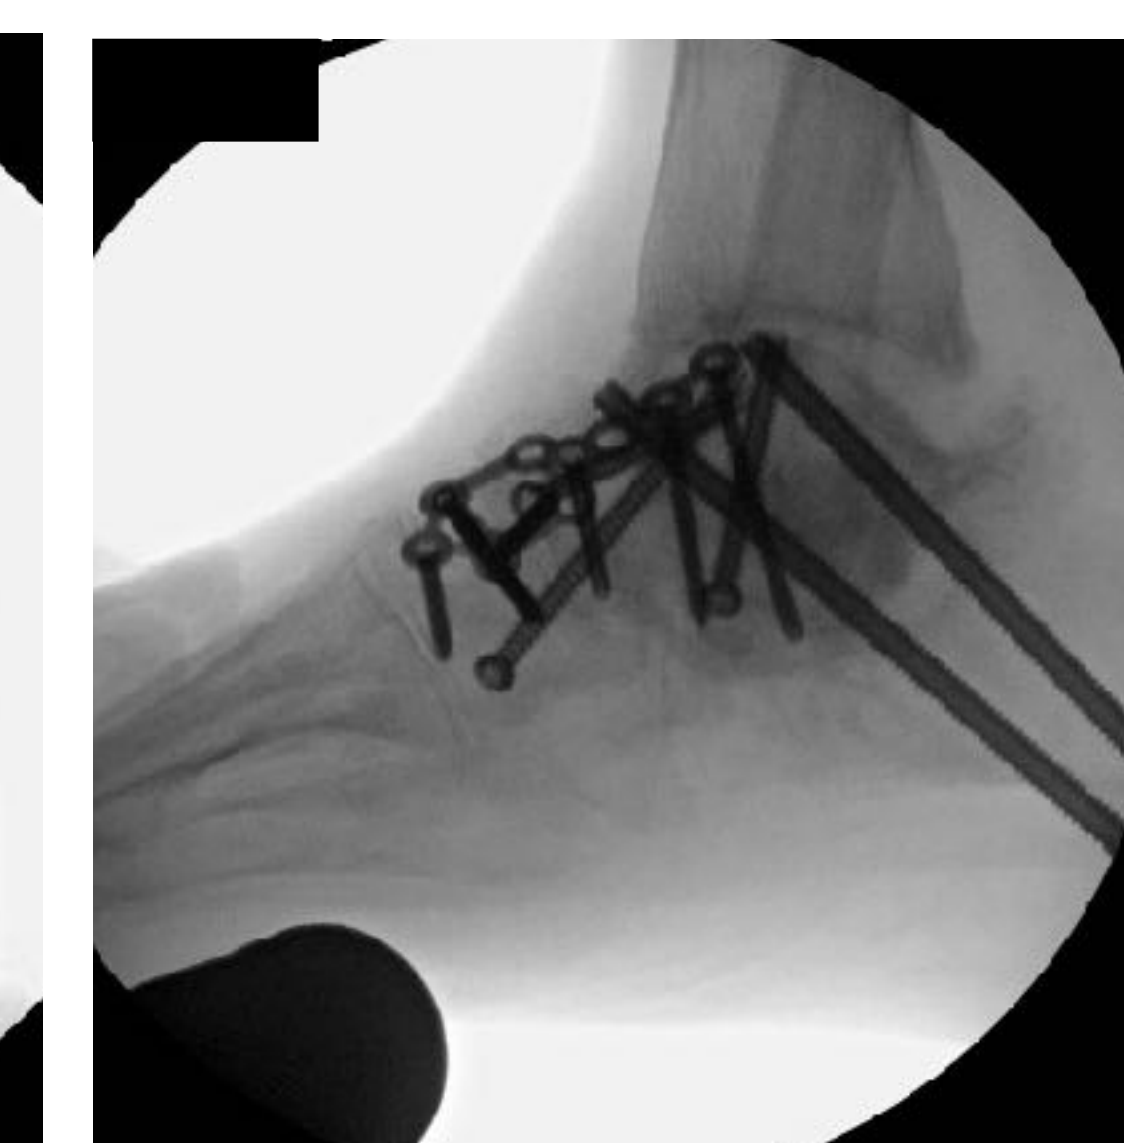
Intra op lateral ankle radiograph demonstrating re-alignment of the foot and ankle into anatomical alignment.
